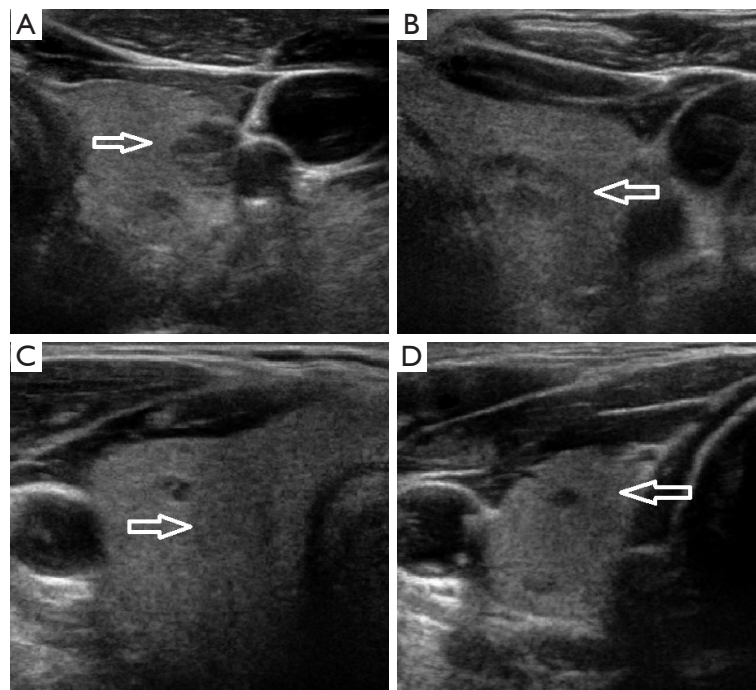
US images of the patient's thyroid gland. (A,B) Transverse US views of the left thyroid lobe with arrows pointing at multiple nodules. (C,D) Transverse US views of the right superior and mid thyroid lobe with arrows pointing at multiple nodules. US, ultrasound.
